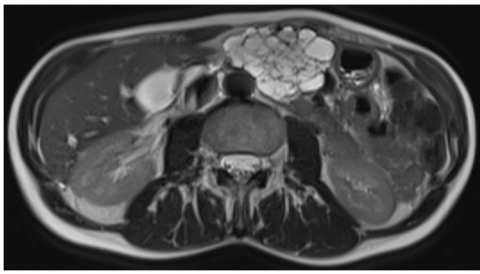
50-year-old woman with serous cystadenoma. T2-weighted non-fat sat sequence in the axial plane shows a multiloculated cystic lesion, with the honeycomb pattern, and lack of communication with the main pancreatic duct.
